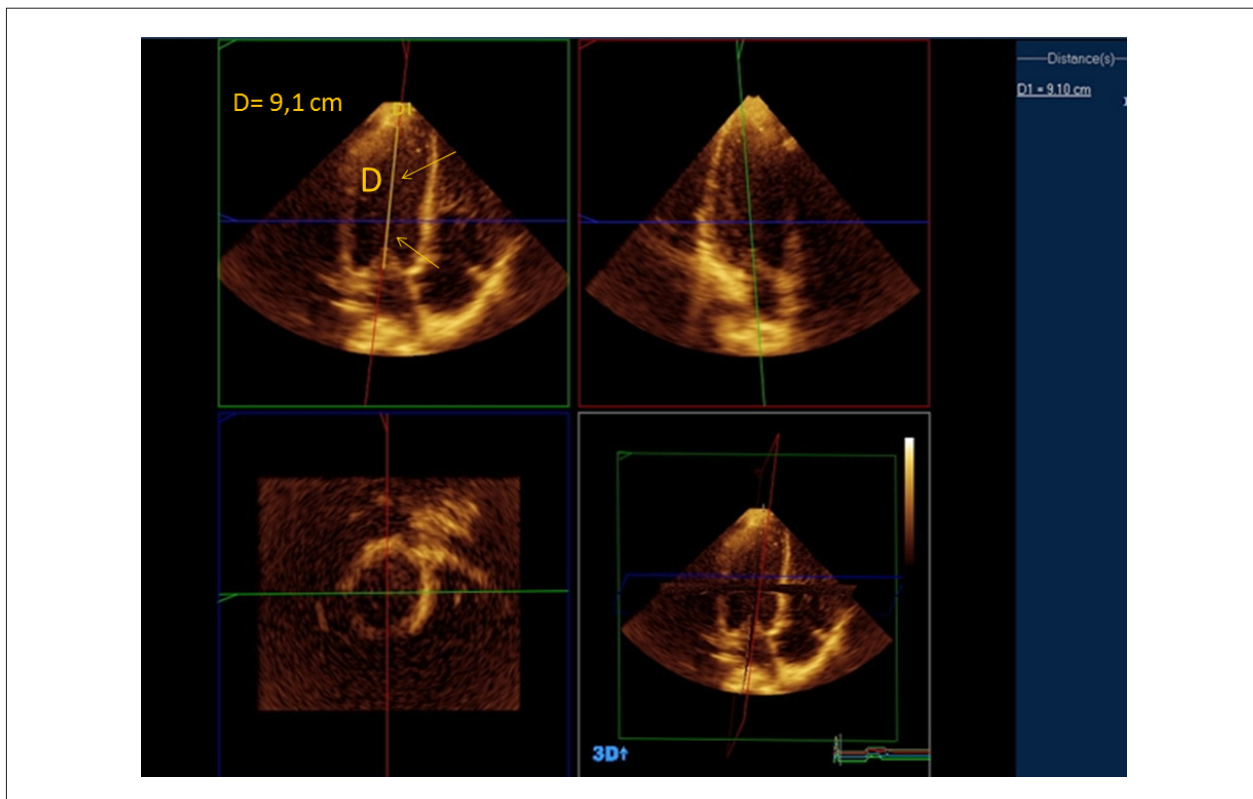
Demonstration of the measurement of the three-dimensional sphericity index (3D SI): 0.26, in accordance with: $3D\ SI = LVEDV / 4/3 \pi (D/2)^3$, for LVEDV: 102.3 mL (Picture 1); (D): 9.1 cm; Arrows: demonstration of the longitudinal diameter of the ventricle in apical four chamber projection.
